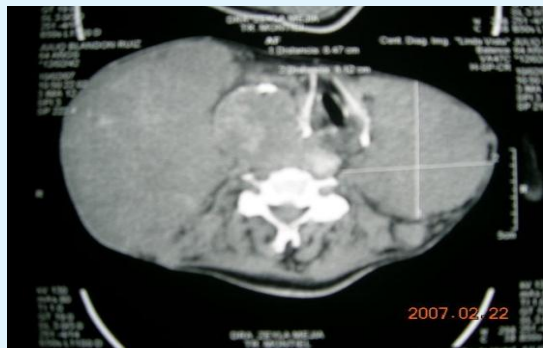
CT scan show thyroid cancer invading right larynx.
